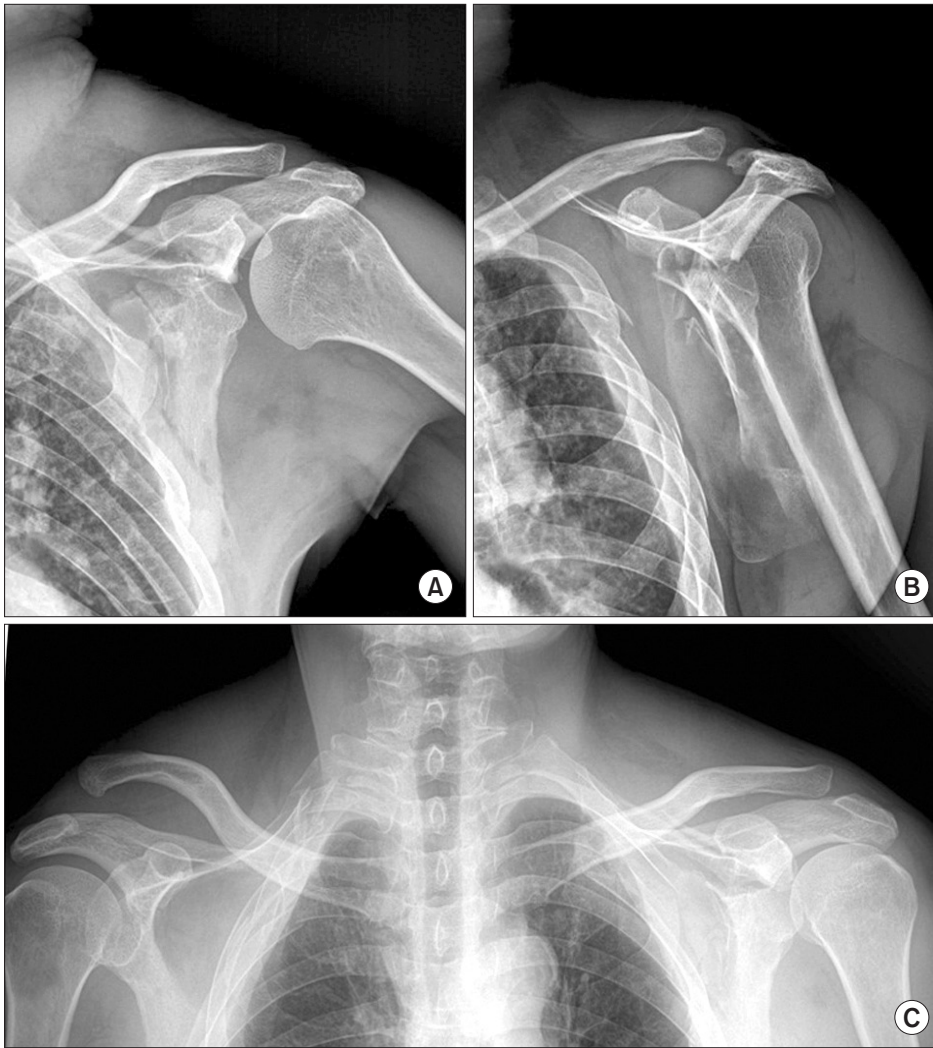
(A) Anteroposterior radiograph of the left shoulder. (B) Lateral view of the left scapular showing a transverse intra-articular glenoid fossa fracture with a comminuted scapular body fracture. (C) Pearson's stress view documenting widened coraco-clavicular distance in the right shoulder, more than 3 times wider compared with the left shoulder.
